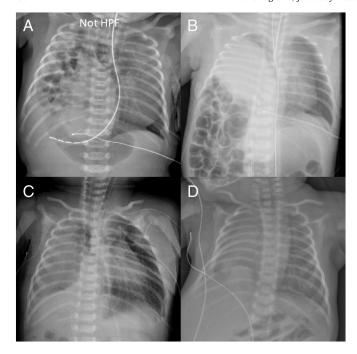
Chest radiographs. A) Neonate with right-sided congenital diaphragmatic hernia without hepatopulmonary fusion (HPF): bowel and liver in the right hemithorax with significant leftward mediastinal shift. B) Female neonate with HPF: liver and bowel in the right hemithorax with slight leftward mediastinal shift. C) Male neonate with HPF: opacification of the right hemithorax without mediastinal shift. D) Male neonate with HPF: opacification of right hemithorax with rightward mediastinal shift.
